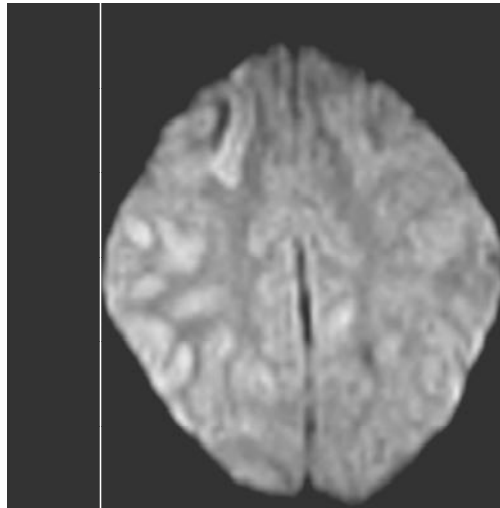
MRI Brain DWI sequence : showing isointense area in the corresponding posterior subcortical region suggestive of vasogenic edema.
